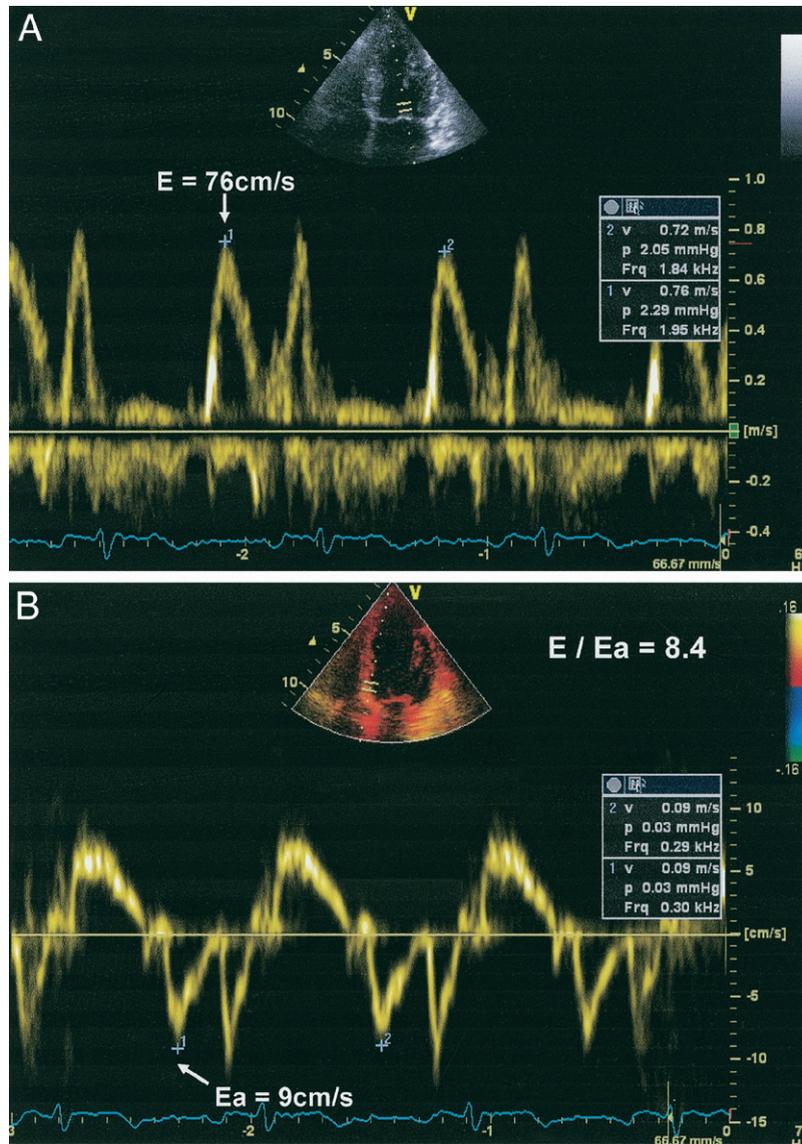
Estimation of Left Ventricular Diastolic Pressure by Tissue Doppler Imaging
